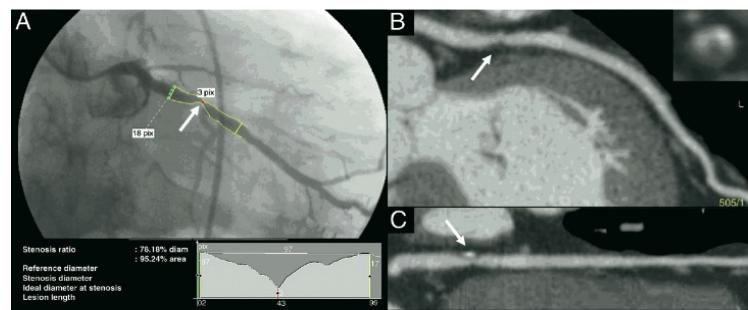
Coronary catheterization (left) compared to coronary CT angiogram (CCTA, right), in the same patient. This image demonstrates the high spatial resolution of coronary plaque/stenosis on CCTA. Early coronary changes can be detected with this non-invasive technique.
